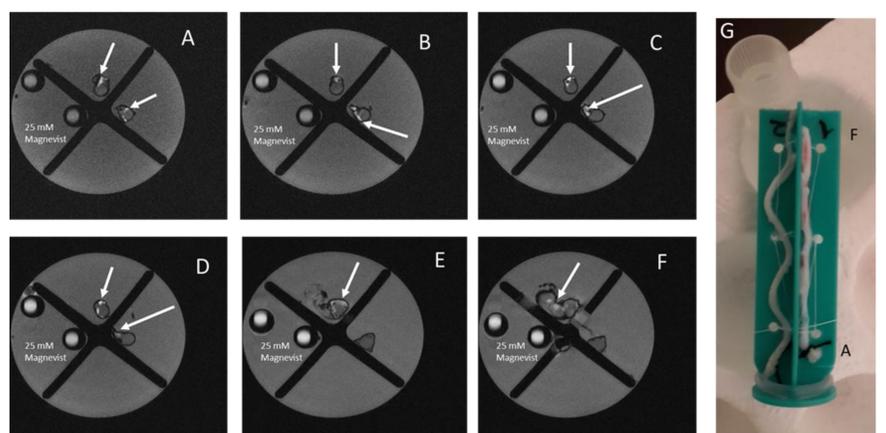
T1 weighted ex vivo MR images using the microimaging insert (7Tesla) of an N. ischiadicus sample (2D IR-Seq: TE= 6.6 ms, TR1= 3500 ms TI= 1000 ms in-plane resolution of 78µm SL 1mm). Cross-sections of two nerves incubated with 10 kDa AD-DTPA-Gd (0.05 mM) versus control tubes filled with gadopentetate dimeglumine (Magnevist, 25 mM) as a positive control. Nerve segments and control tubes were placed in a syringe (G) and measured by MRI. Images shown start from the distal part (A) to the proximal (F) end of the nerve. Six out of a total of 30 slices are shown. The contrast-to-noise ratio (CNR) between the epineurium (the nerve rim) (white arrows) and the non-enhanced inner region of the nerve is about 41. Note the strong signal enhancement coming from the epineurium, which demonstrates the active transport reaching up to the spinal cord entrance (proximal nerve site F) after the application of a 500 times lower Gd concentration compared to the positive control (25 mM Magnevist).
